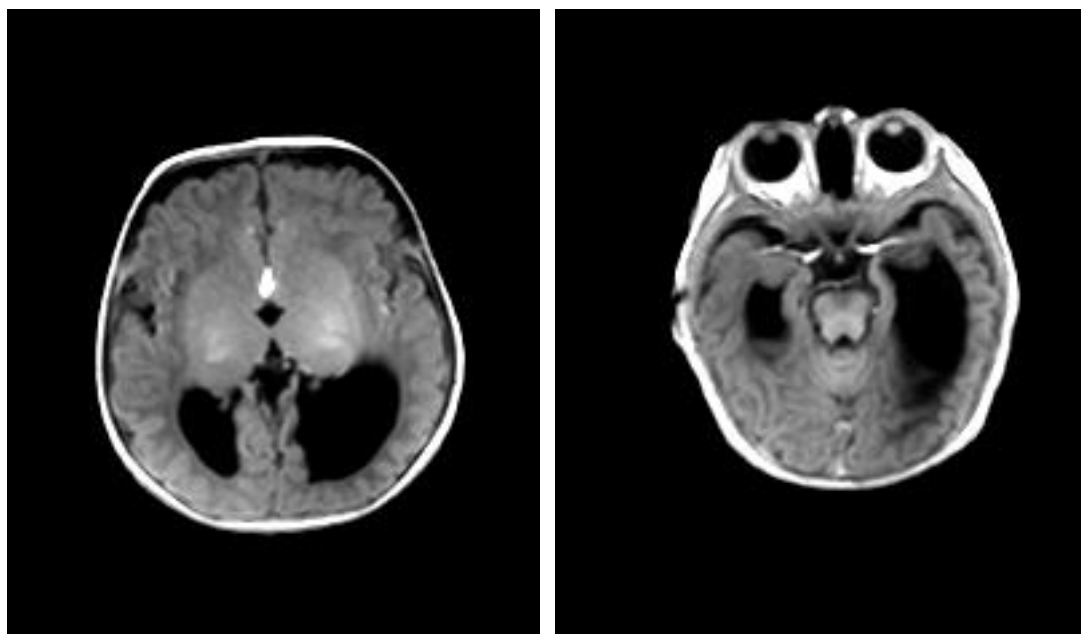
8 :Axial FLAIR image showing peri-callosal lipoma with non visualization of the frontal horn of lateral ventricles.
